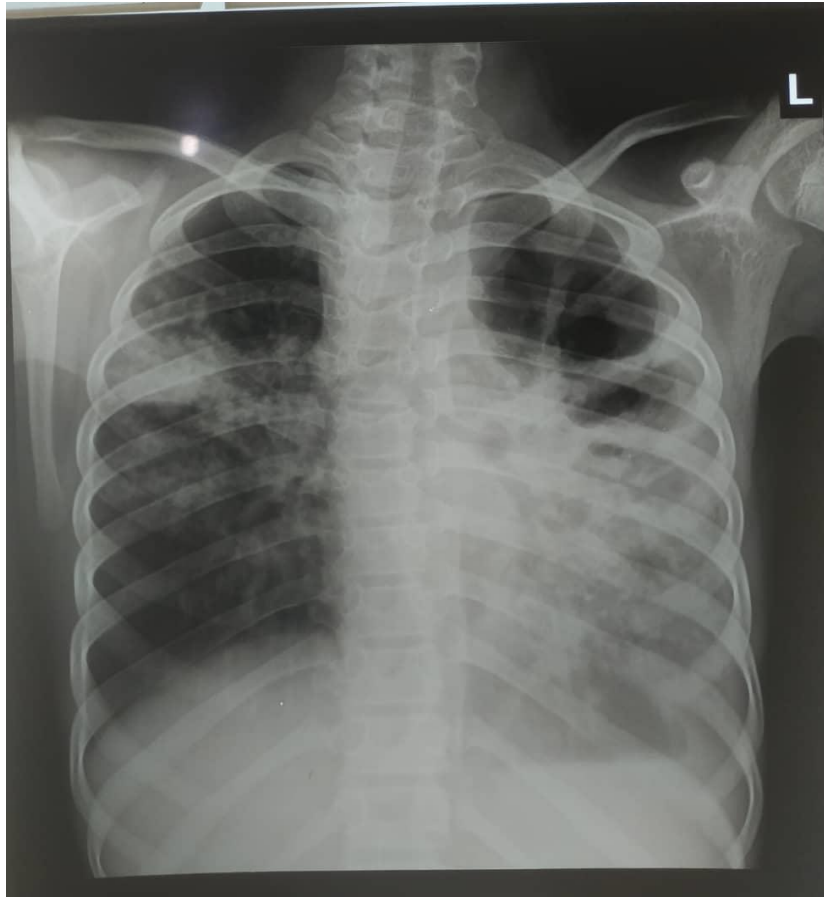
Chest radiograph showing cavitary lesions within both upper lung zones with adjacent reticular and patchy opacities. It also shows homogeneous opacification of the left middle and lower lung zones with obliteration of the left cardiac silhouette, diaphragmatic outline and costophrenic angle in keeping with pleural effusion with ipsilateral mediastinal shift.
